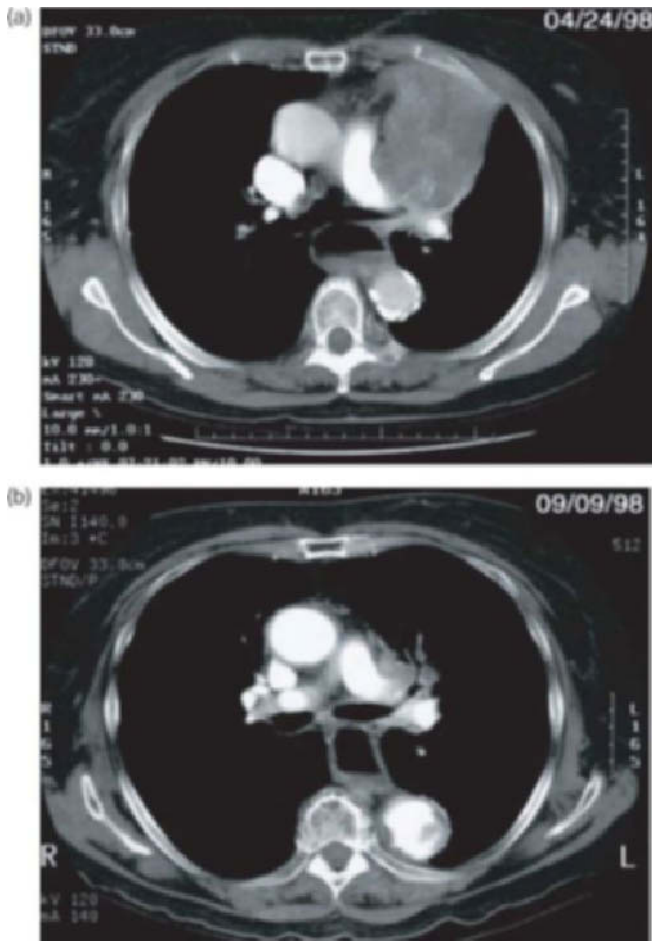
Endobronchial Ad.wt p53 injection and radiation therapy. (a) Baseline chest CT scan of Patient 2 who had a respectable left upper lobe mass. Patient 2 received three bronchoscopic injections of Ad.p53 (3×10^{11} vp) in combination with radiation therapy (60 Gy). (b) Repeat CT chest scan 3 months after completion of therapy. Pathologic biopsies obtained at that time were negative for viable tumor. Reproduced from [51] with permission.
